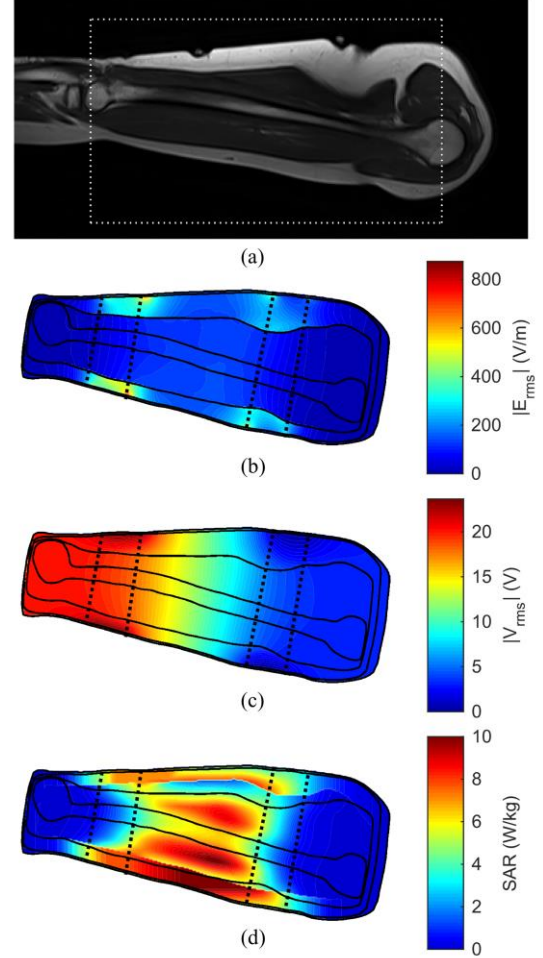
Examples of MRI, computed electric field, electric potential and projected SAR distributions, and power transfer experimental results. Black dashed lines indicate the positions of the external electrodes. (a) MRI image of the arm of participant P3 (i.e., A3), b-d were computed inside the white-dashed box of the same participant. (b) Computed electric field distribution. (c) Computed electric potential distribution. (d) Computed projected SAR distribution.
